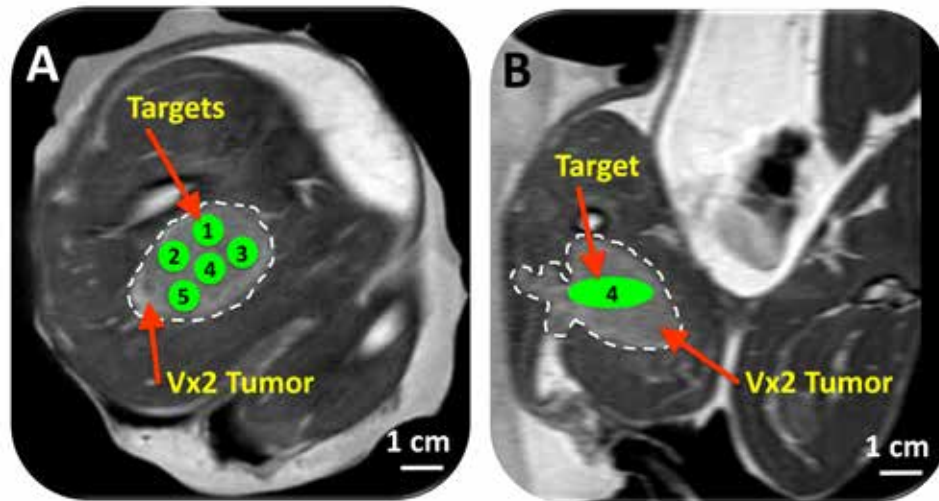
Planning for MRI-guided mild hyperthermia: A) Coronal MR image, B) Sagittal MR image. Tumor (hyper-intense) was identified (white dashed line) on the proton density-weighted planning images, and target regions within the tumor were chosen (green circles). Image reproduced with slight modifications from Publication II with permission from AAPM.
